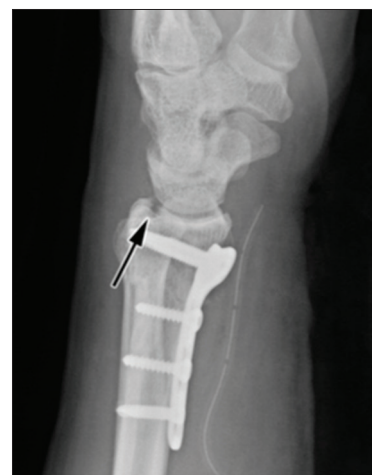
Lateral view plain radiograph showing a fractured dorsal rim fragment still displaced by 2.8 mm (arrow) after volar plate fixation
